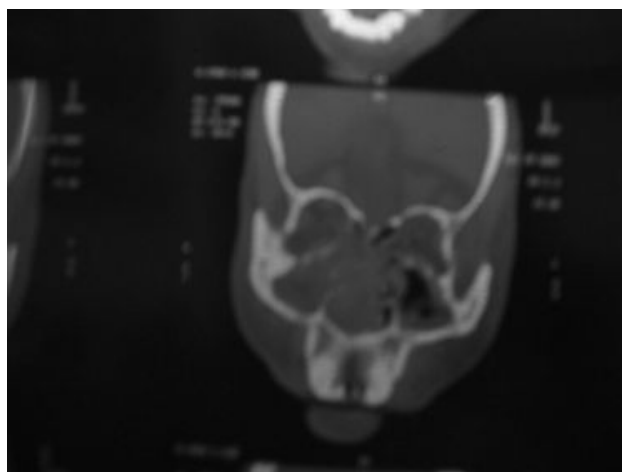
CT Scan showing tumor completely filling right nasal cavity, choana, Maxillary and ethmoid sinuses.
